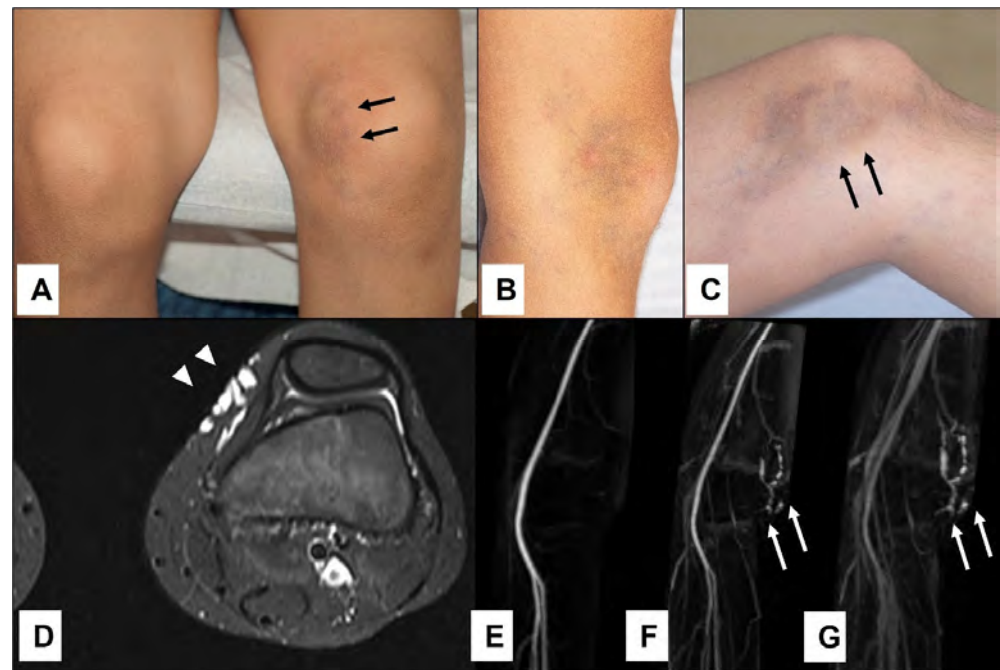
An 11-year-old boy presented with bluish swelling medially on the left knee (A): white (arrowheads). The lesion was compressible and would drain and flatten with the elevation of the leg indicating clinically the venous malformation (B,C)—(white arrowheads). MRI showed the exact location and extension of tubular-cystic venous malformation (D)—(white arrowheads), which filled with contrast material in the venous phase of the MR angiography (E–G)—(white arrows), confirming the clinical diagnosis. The patient was referred to sclerotherapy.
